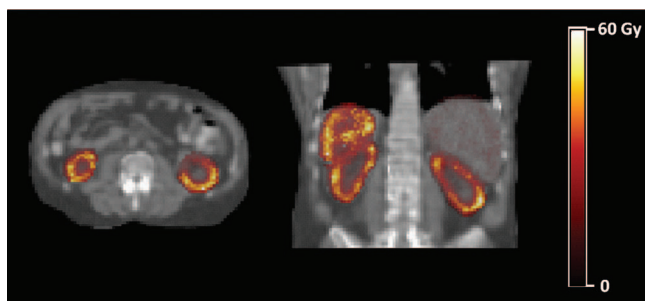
Axial and coronal sections of the ^{90}Y absorbed dose in Gy for the whole SPECT field of view shown against a CT background.
